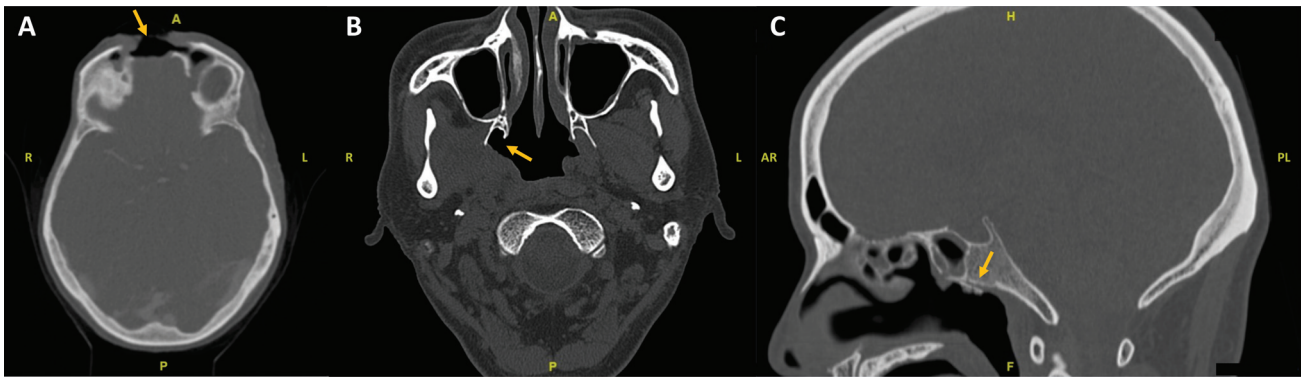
CT images of ORN findings. (A) Osteolysis of the frontal sinus of patient A. (B) Exposed bone at the right pterygoid plates of patient B. (C) ORN of the clivus of patient B. CT, computed tomography; ORN, osteoradionecrosis.
